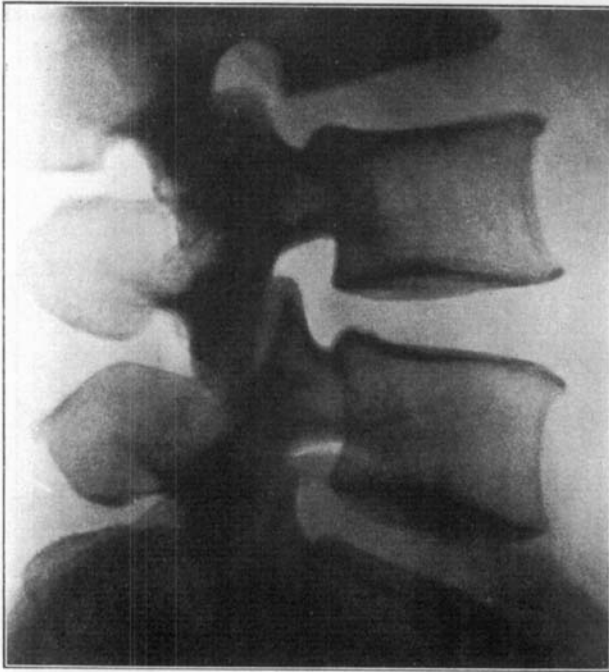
Roentgenogram showing details of lumbar vertebræ. Both the vertebral bodies and the spinous processes stand out perfectly.
